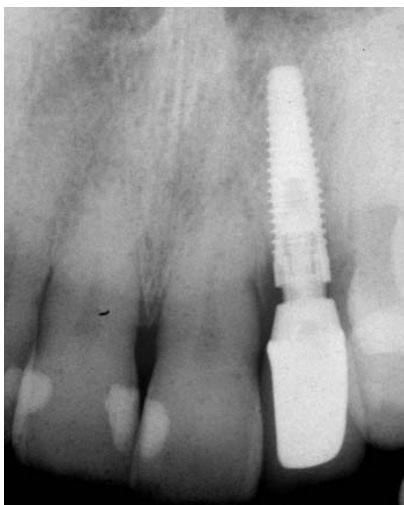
Periapical radiograph showing incomplete seating of the definitive abutment. Note also the loss in density of the crestal bone around the fixture head.
